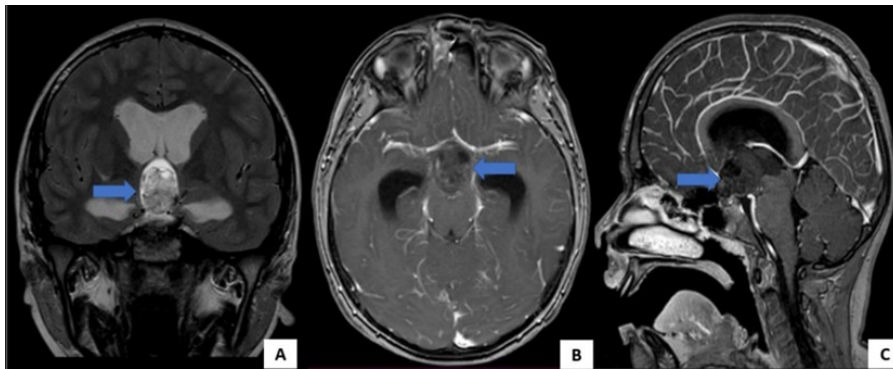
Brain MRI (pre-surgical study) coronal (A), axial (B) and sagittal (C) section respectively shows a T2 sequence image of solid and cystic features at the suprasellar level with diameters of 33mm, 22mm and 20mm, in sequence. Contrast T1 shows minimal peripheral enhancement.
